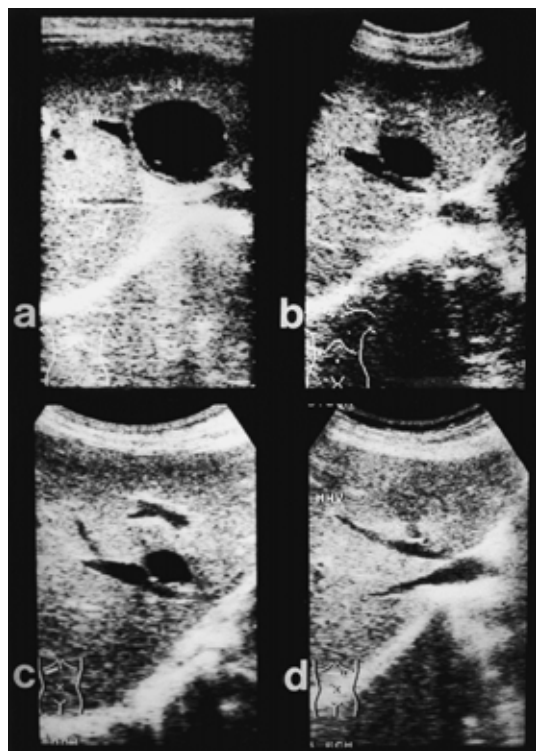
Ultrasonography (a) 40 mm in diameter in June 1994. (b) 25 mm in diameter in May 1995. (c) 10 mm in diameter in September 1995. (d) No hepatic cyst was visualized in December 1996, though the region in the area of the cyst appeared hyperechoic.
